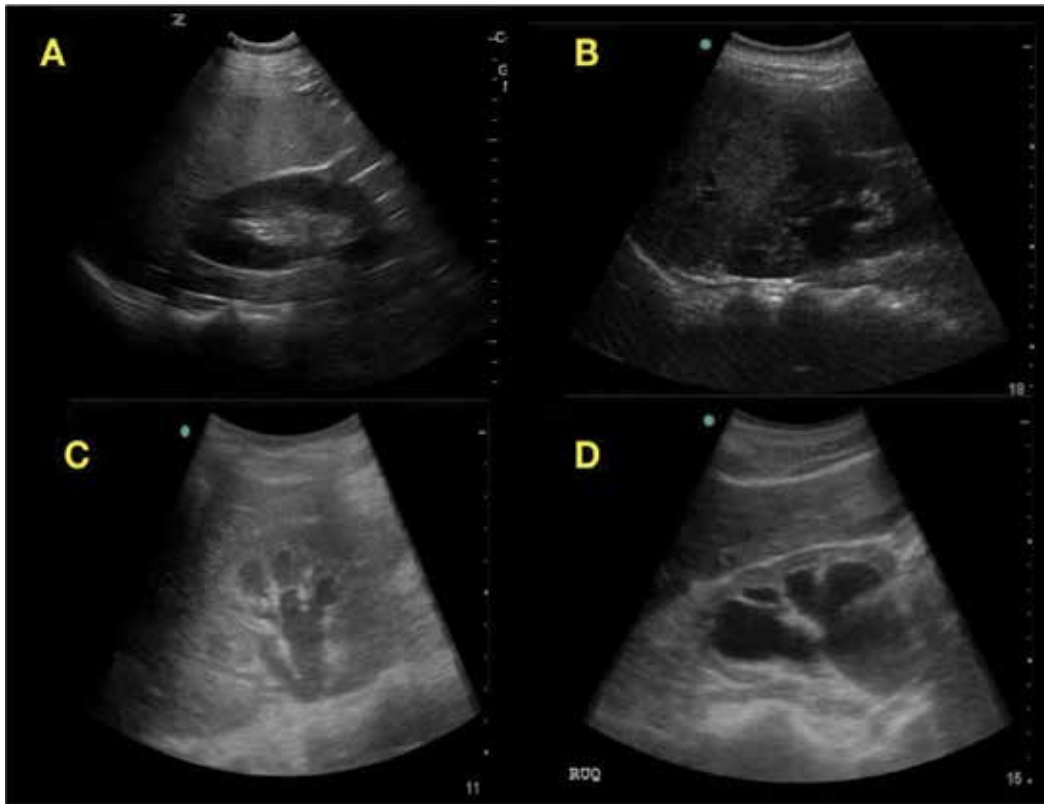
(A) Normal renal ultrasound, (B) mild hydronephrosis (only the renal pelvis is filled with fluid), (C) moderate hydronephrosis (fluid-filled renal pelvis extending to the renal calyces), (D) severe hydronephrosis (entire renal collecting system is dilated).
